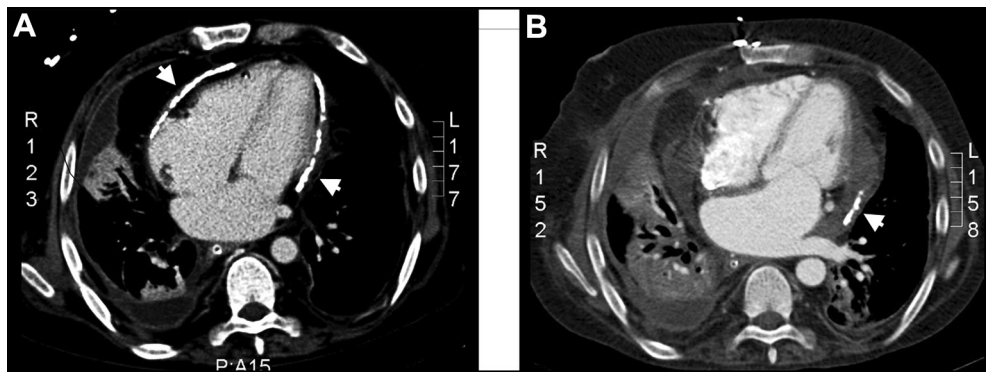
(A) Computed tomography identified diffuse calcification and thickening of the pericardium (arrowheads). (B) Pericardial tissue (arrowhead) remained after pericardiectomy.
